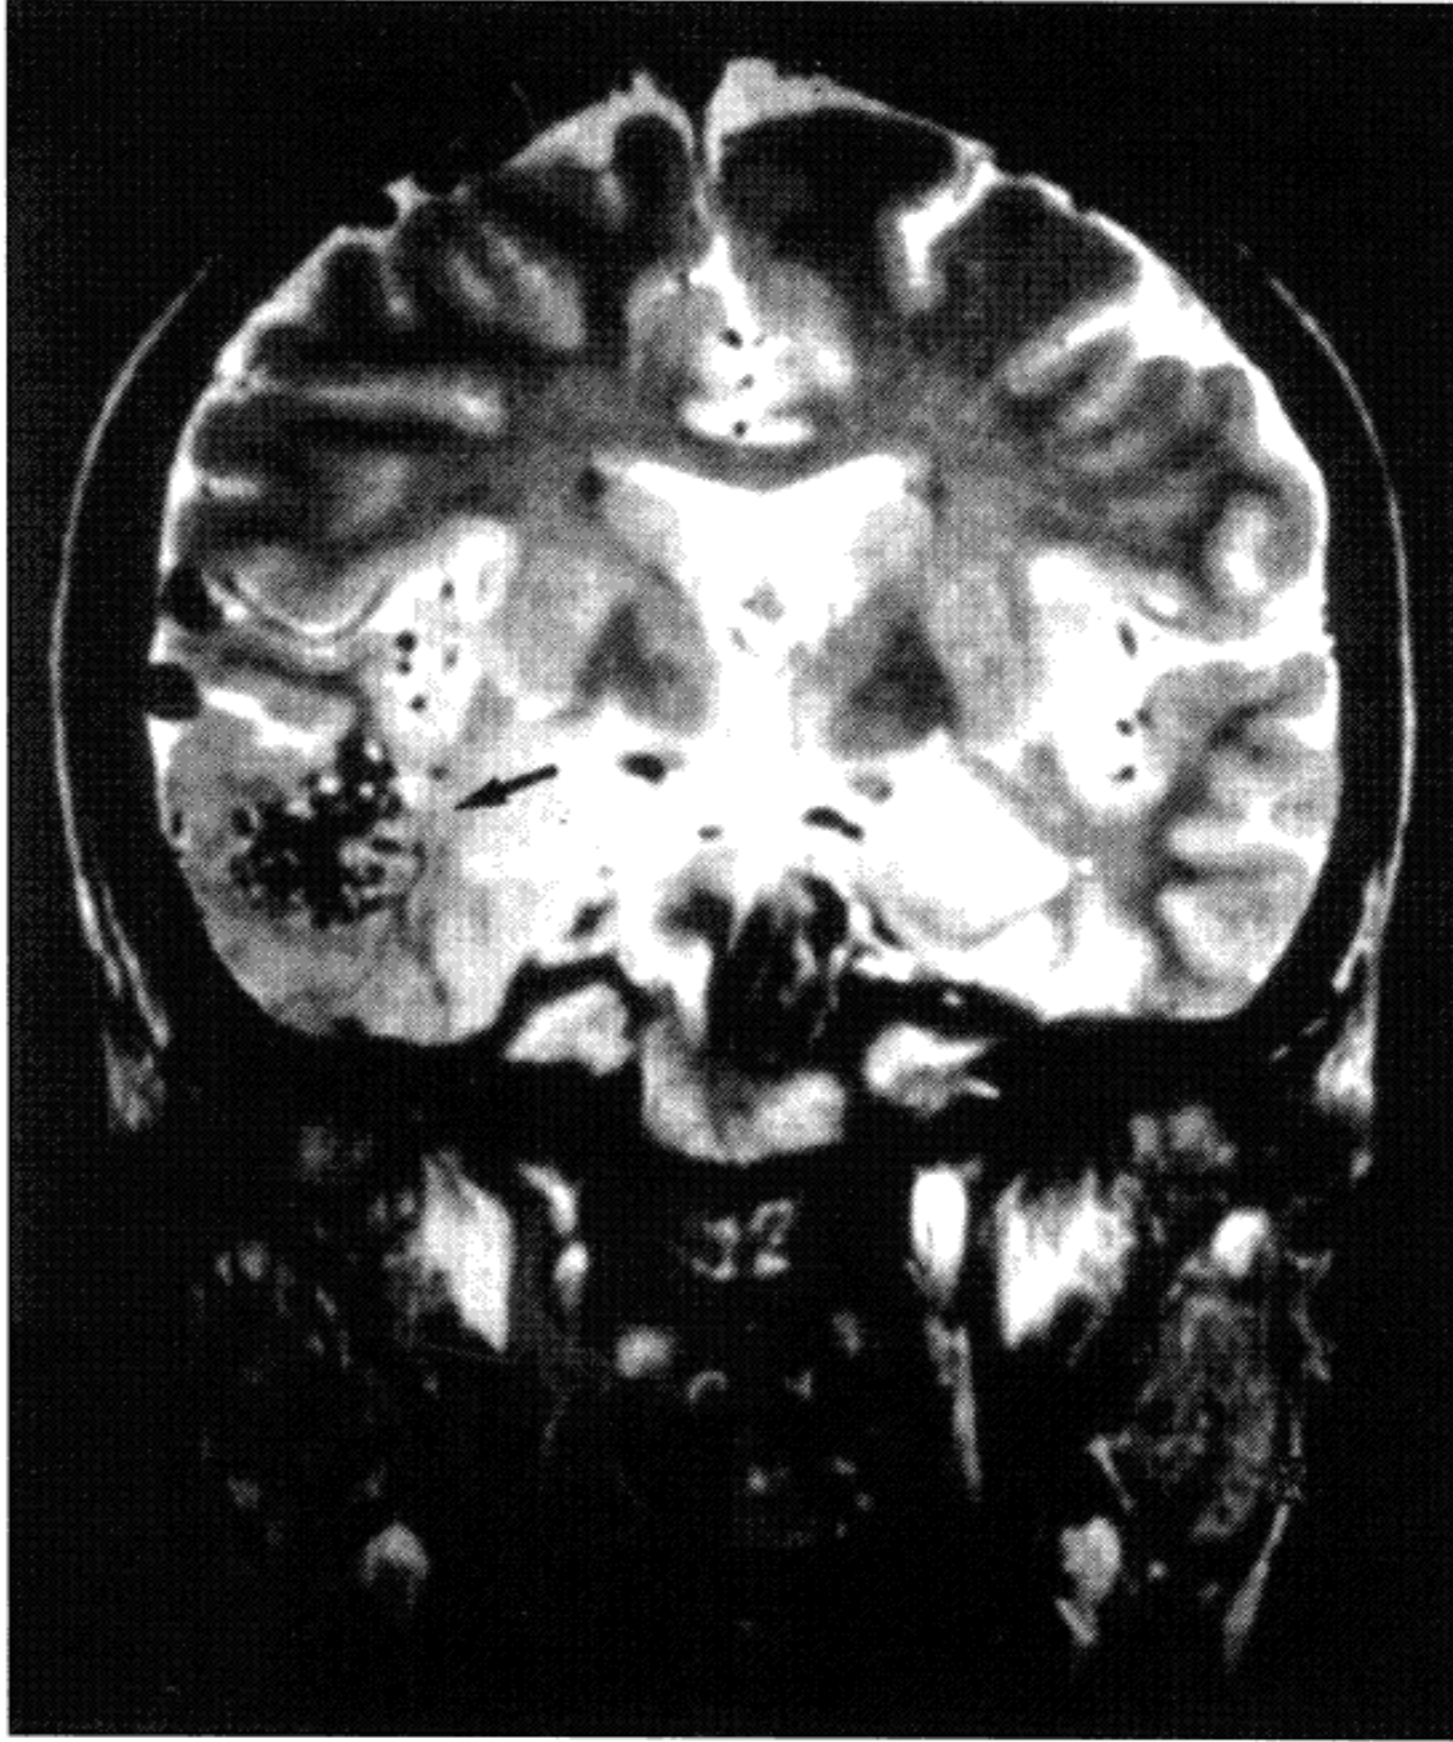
T2-weighted coronal MRI showing an arterio-venous malformation in the right temporal lobe with enlarged draining veins.
